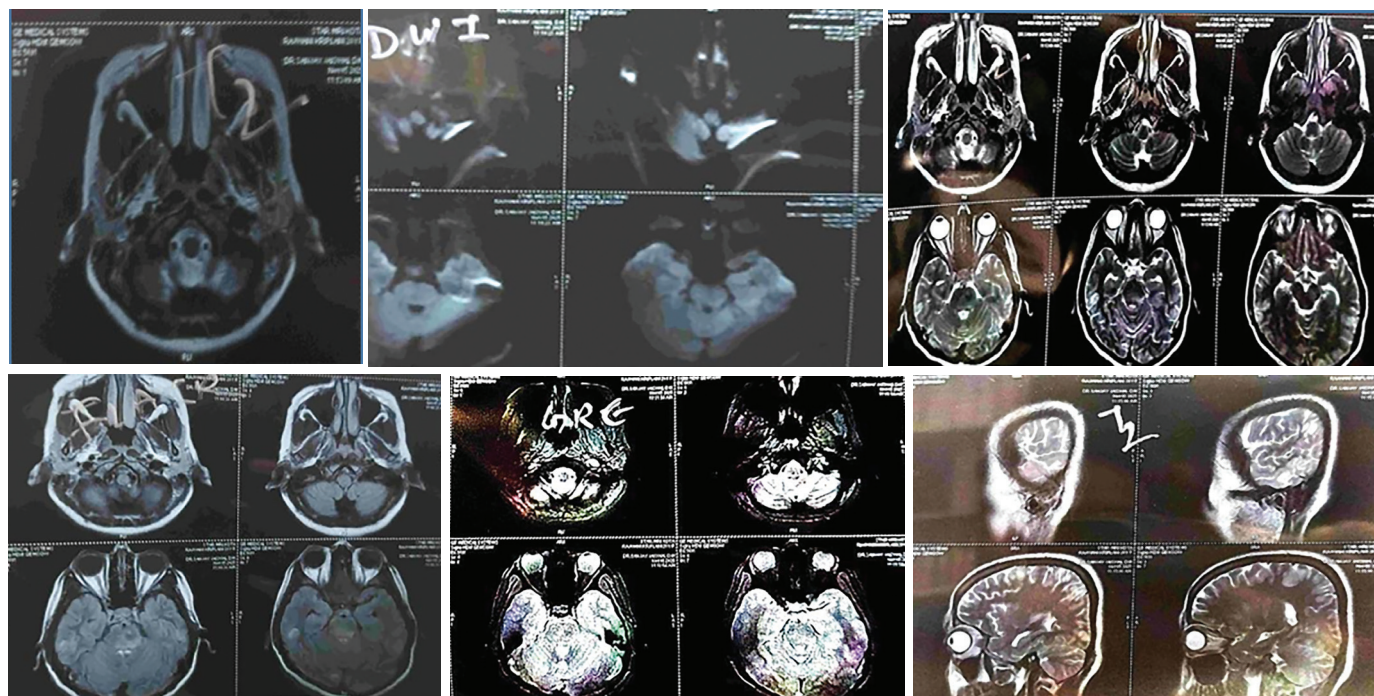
Brain MRI showing symmetrical bilateral parieto-occipital predominant hyperintense lesions, consistent with posterior reversible encephalopathy syndrome (PRES).
